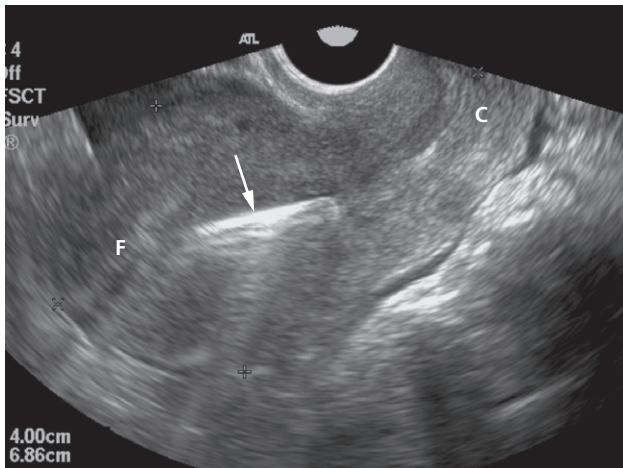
Intrauterine contraceptive device (arrow) seen as a linear reflective echo within the uterine cavity, shown on a longitudinal ultrasound scan. C, cervix; F, uterine fundus.
